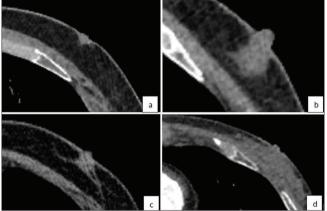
CT images showing patterns of gynecomastia in the male breast. Examples of non-gynecomastic normal retroareolar area (a), nodular pattern (b), dendritic pattern (c), and diffuse glandular pattern (d) of gynecomastia
